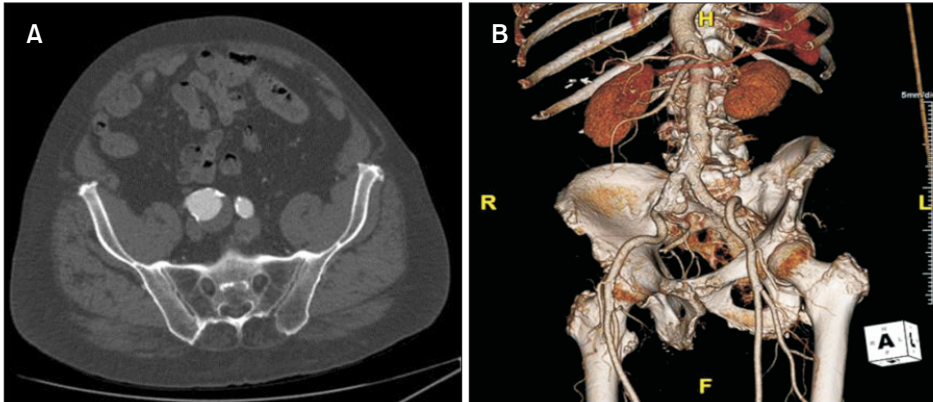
Isolated right common iliac aneurysm (A) CT axial section and (B) 3D-reconstruction.
